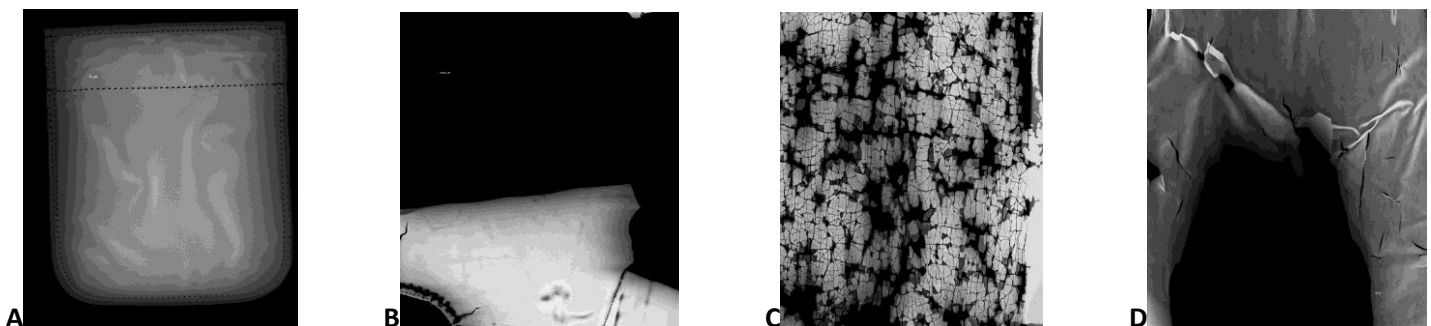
Radiographic images of the protective shield showing different types of defects. Free from defects (A), Splits (sagging), cracks, tears, and holes (B, C, and D)
